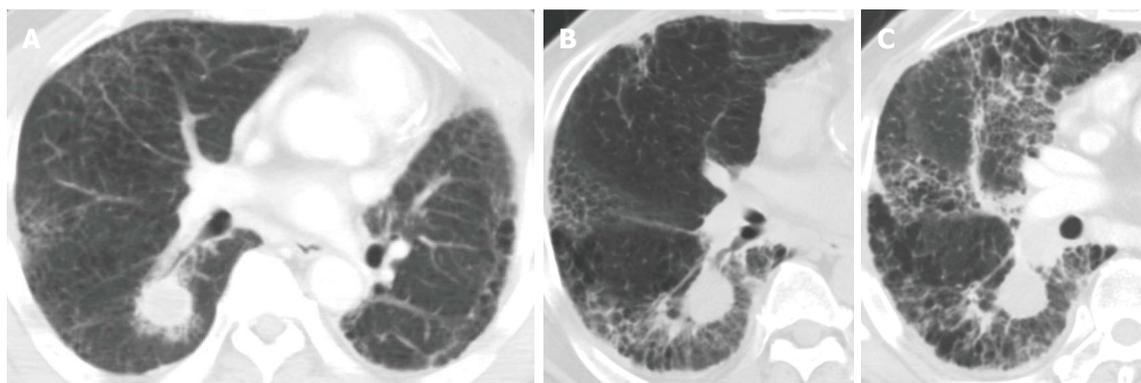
Computed tomography image. A: Before stereotactic body radiation therapy (SBRT) but after surgery for a left lung cancer. The nodule in the lower lobe of the right lung (S6) increased to 23 mm; B: Taken at post-SBRT month 5; C: Taken at post-SBRT month 7. Acute exacerbation of interstitial pneumonitis was found.
